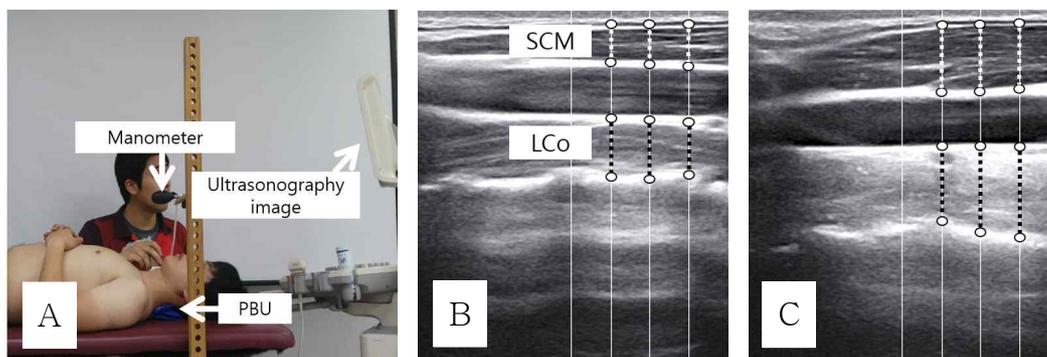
PBU measurements using a hand-held manometer and ultrasonography recordings (A: measurement setting, B: ultrasonography image in the resting position while adopting a HHP, C: ultrasonography image while performing CCF at a pressure of 30 mmHg, PBU: pressure biofeedback unit, SCM: sternocleidomastoid, LCo: longus colli).
